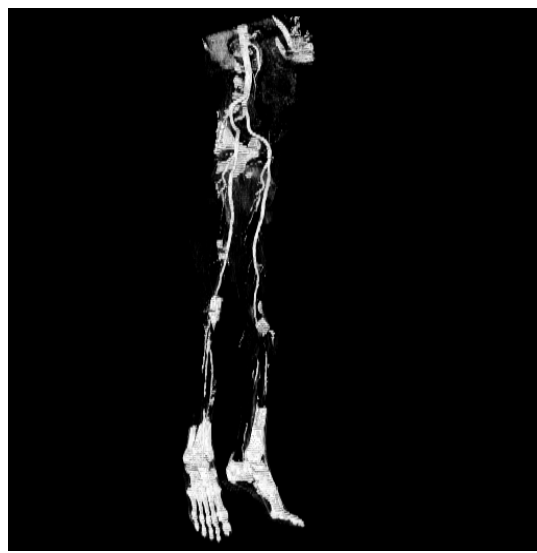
3-D CT angiogram
